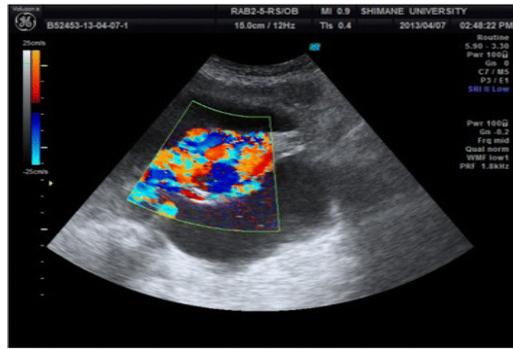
Ultrasound doppler image of the blood flow.
